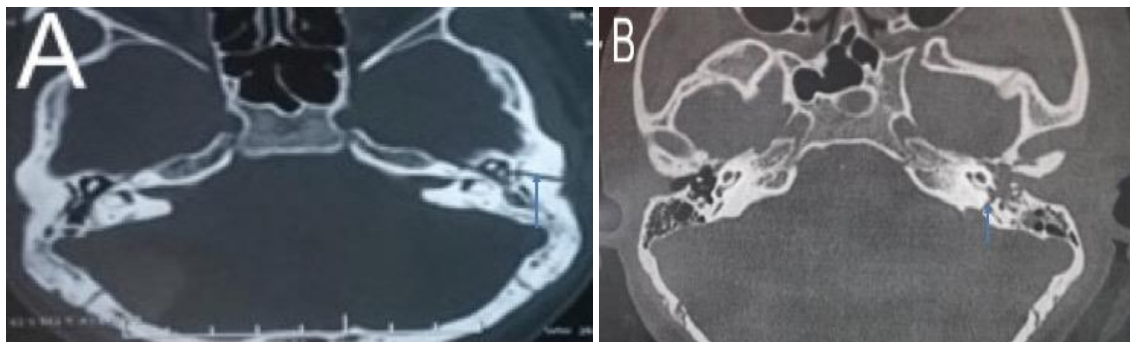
Axial HRCT scanning of the temporal bone (A) Left otic sparing fracture showing fracture involving squamous part of the temporal bone and 1st genu with disrupted incudo-malleolar joint, (B) Left otic fracture showing fracture involving the inner ear with disrupted ossicles.
